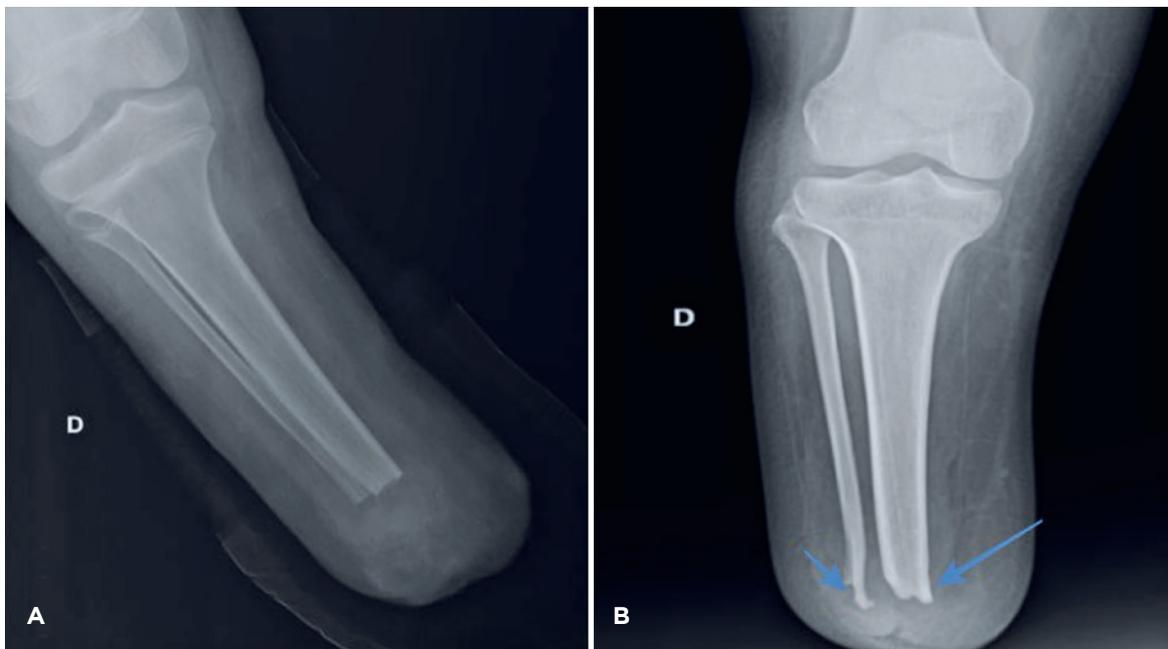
Radiographic images of the right transtibial amputation stump in a child. (A) The stump is shown immediately after the initial amputation procedure, with the proximal growth plates of the fibula and tibia open (B) 43 months postoperatively, prominent bone spurs (blue arrow) are visible at the distal end of the stump.
